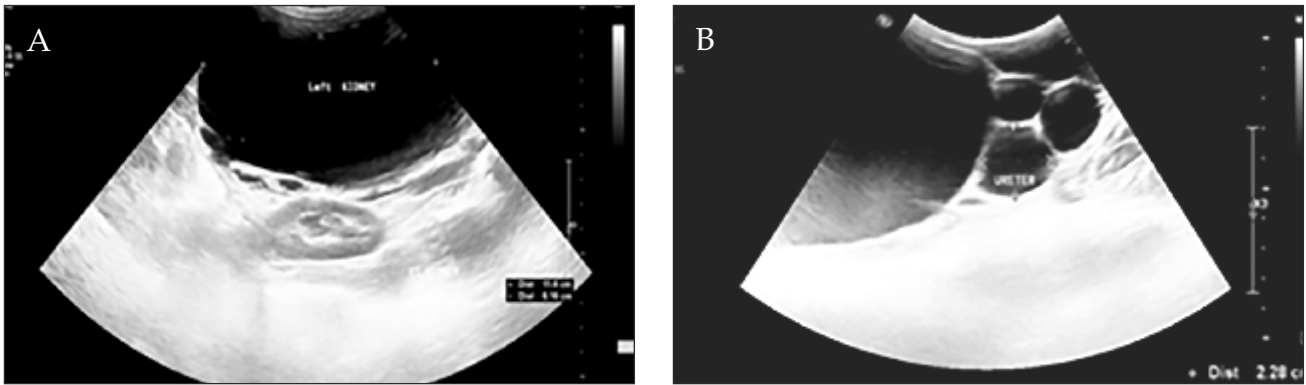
(A) Ultrasonographic image of hydronephrotic image characterized by thin cortex and loss of cortico-medullary differentiation; (B) Ultrasonographic image showing presence of dilated ureters measuring up to 2.28 cm in diameter.
